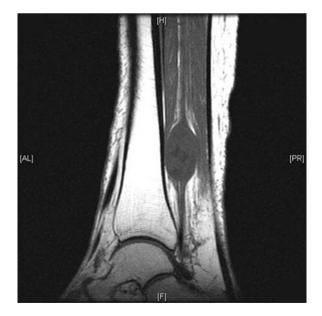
T1 weighted sagittal MRI image of a posterior tibial nerve schwannoma
